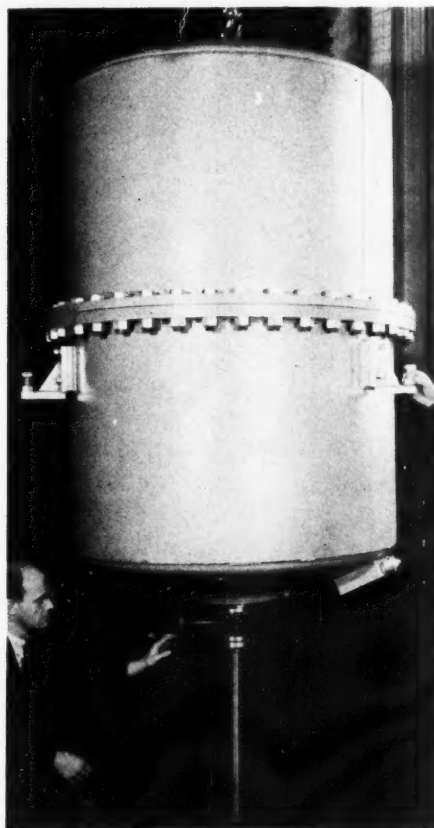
Million-volt x-ray unit.
